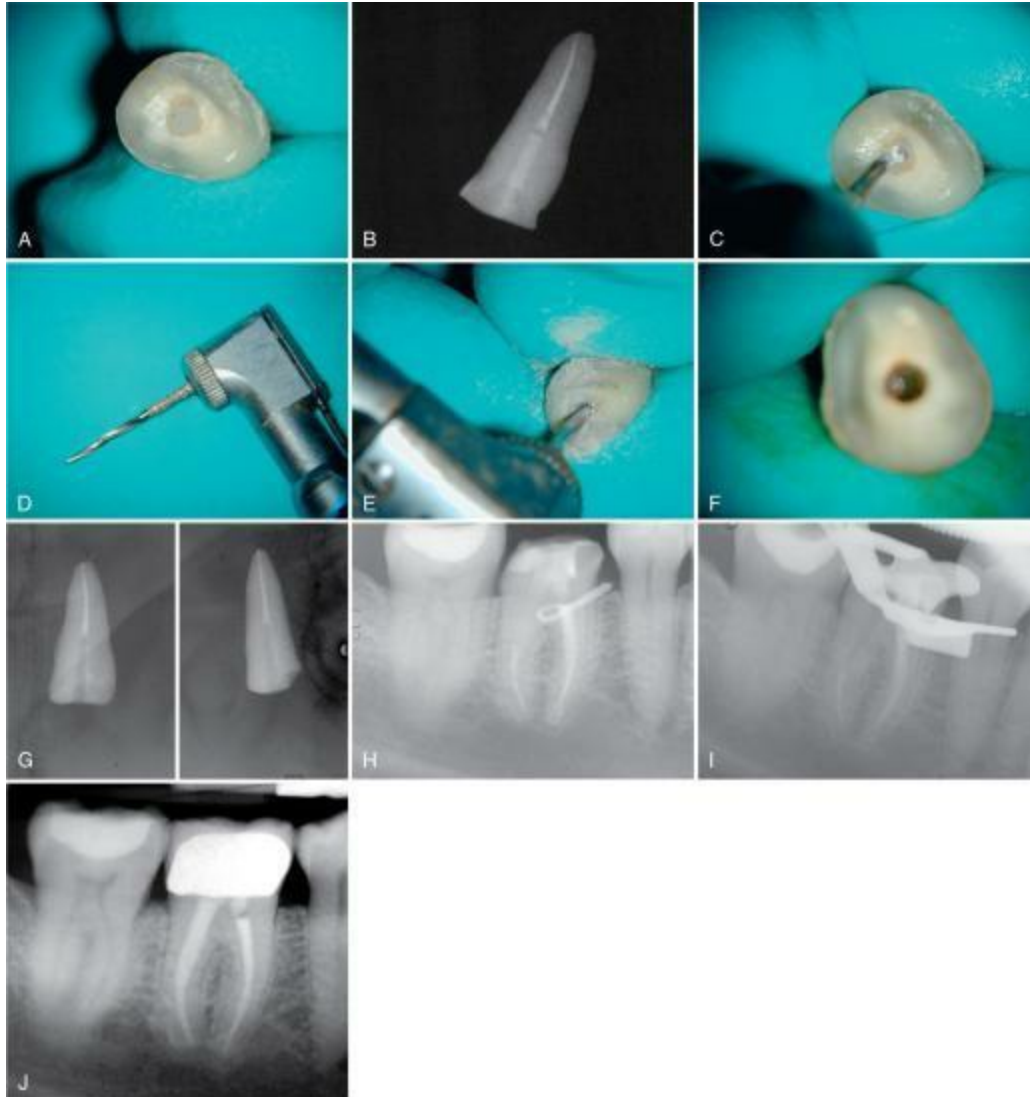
GyroTip technique. A, Broken fiber post in an extracted tooth. B, Radiograph of test tooth with post in place. C, Creating a pilot hole. D, GyroTip instrument. E, GyroTip cutting through the fiber post. Note alignment with long axis of post. F and G, Post removed. H, Clinical case showing fiber post perforation into furcation area. I, Post removed with the GyroTip. J, One-year follow-up of MTA repair.
